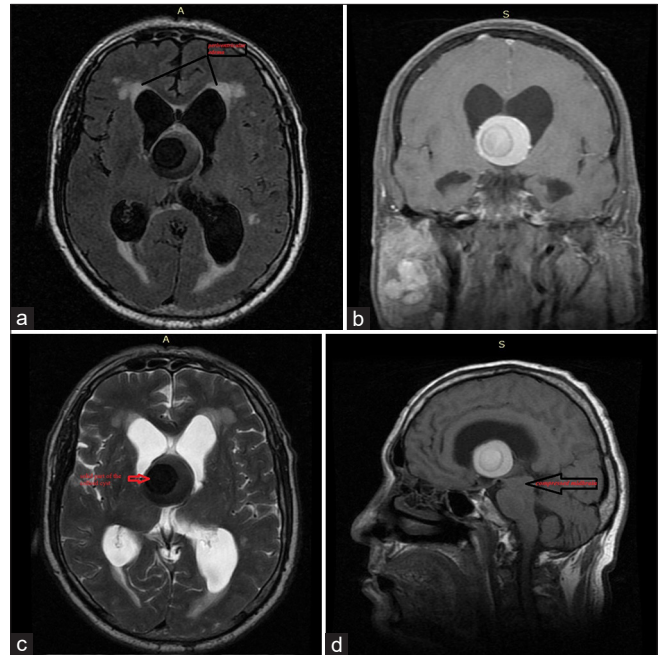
The brain magnetic resonance imaging of the patient before the operation. (a) Axial T2 FLAIR; (b) T1 coronal with contrast; (c) T2 axial; and (d) T1 sagittal. (a) The arrows show the signs of a periventricular edema of the anterior corn of the lateral ventricle. (a and c) Signs of hydrocephalus and edema of the anterior and posterior horn of the lateral ventricle. (c) The arrow shows a solid part of the colloid cyst (CC). (d) The black arrow shows a giant CC, which is pressing against the midbrain from above.
